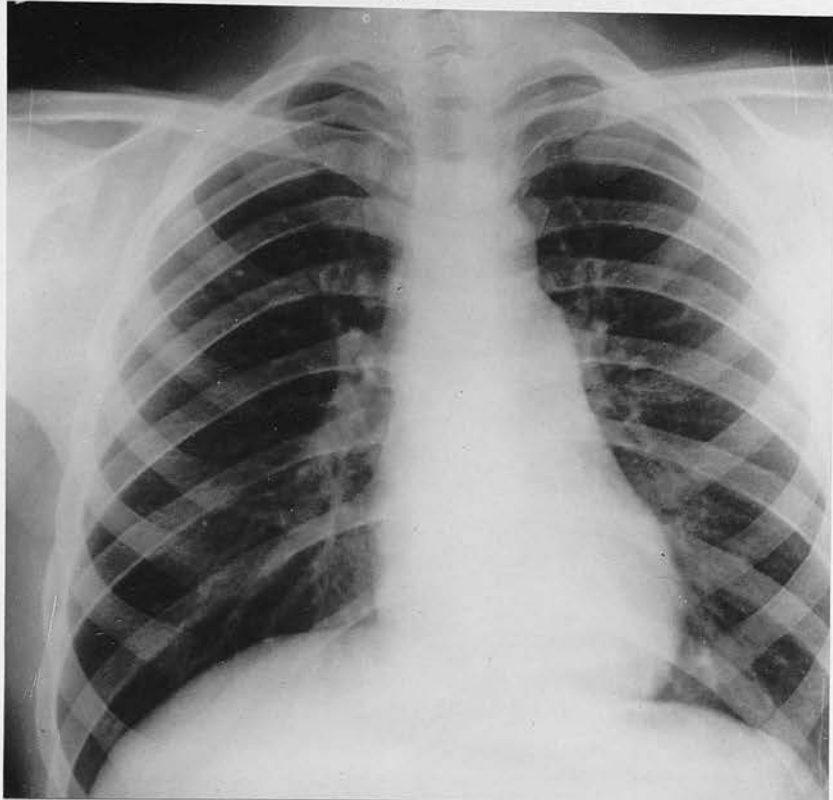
Radiograph of Case 61. True reduction in cardiac size following ligation of Patent Ductus Arteriosus at 11yrs.
